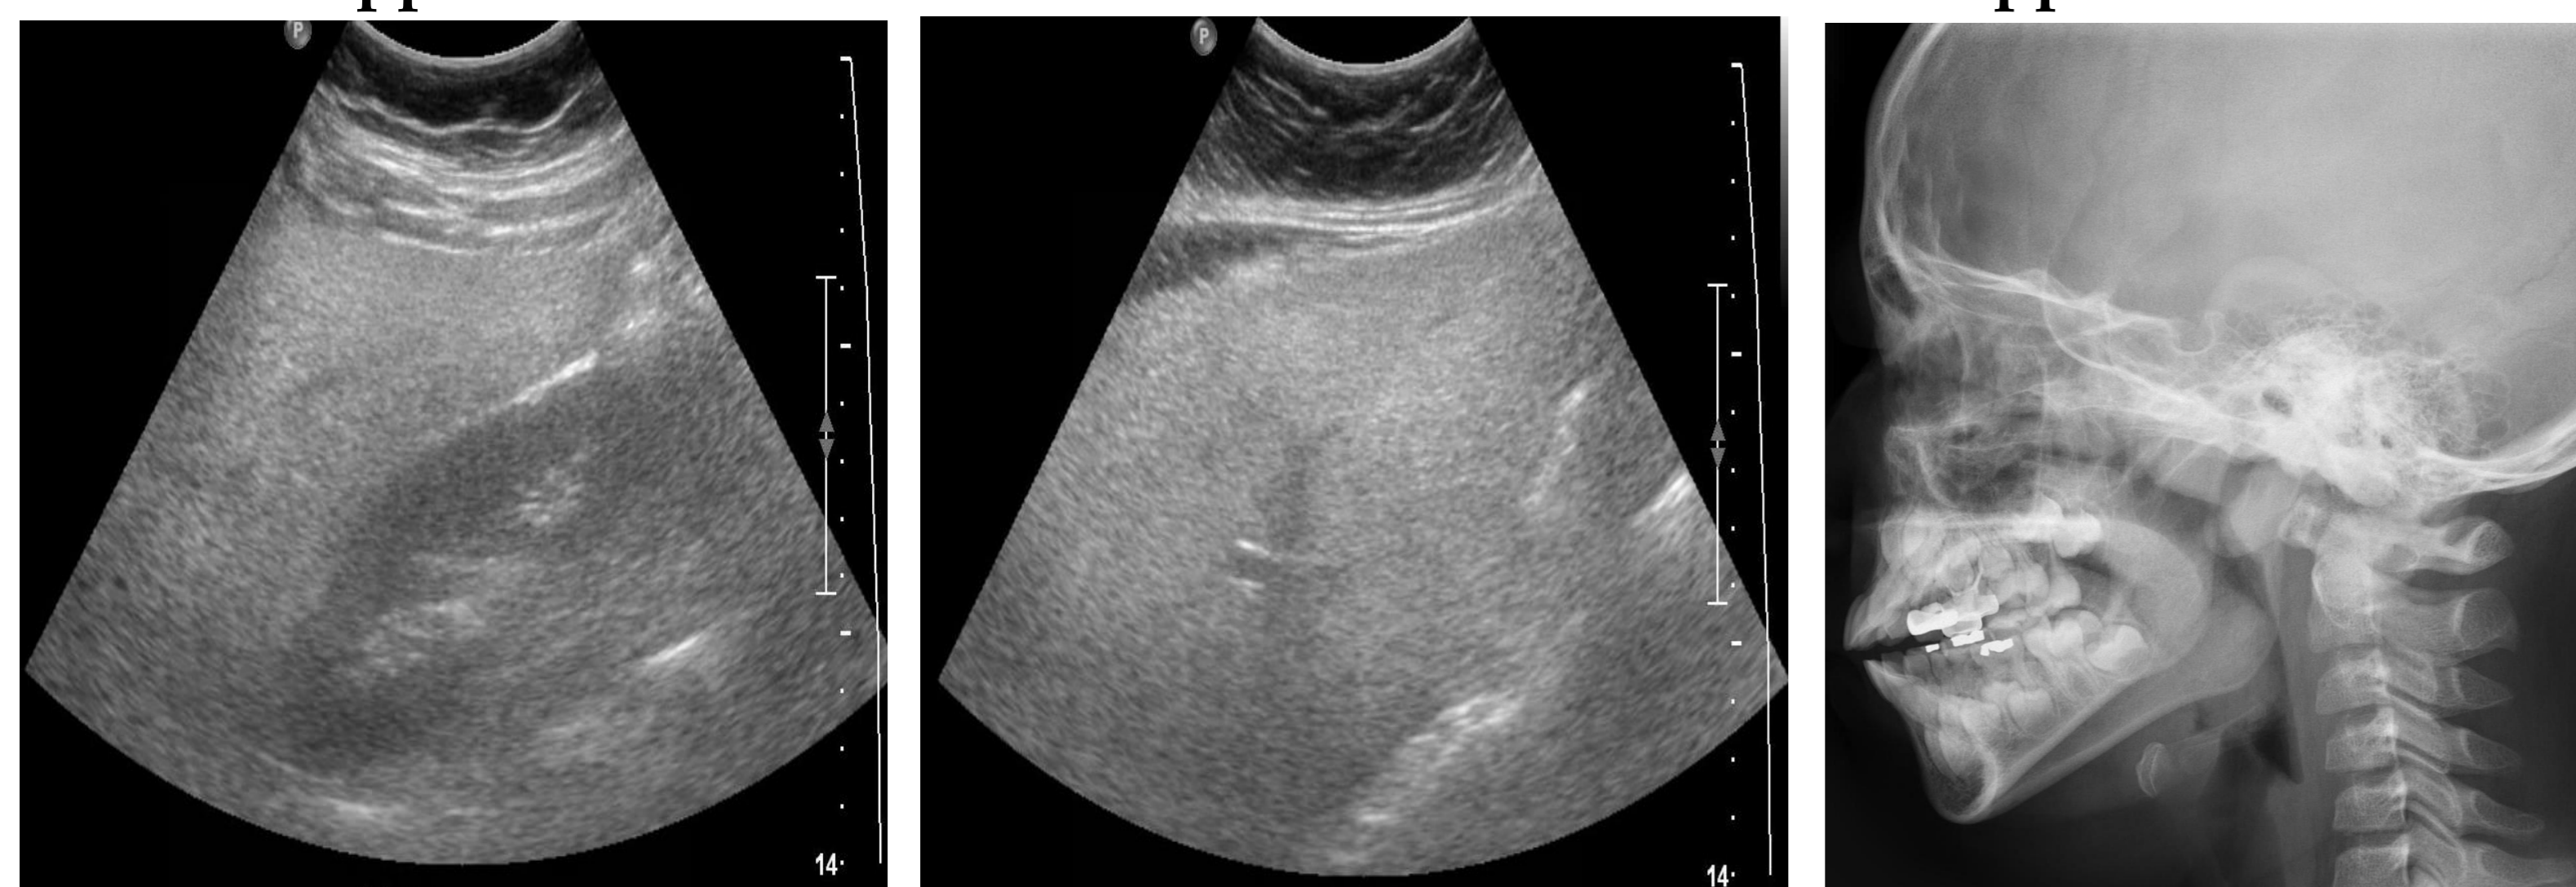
Moderate fatty liver in abdominal sonography, Tonsillar hypertrophy in PNS xray
